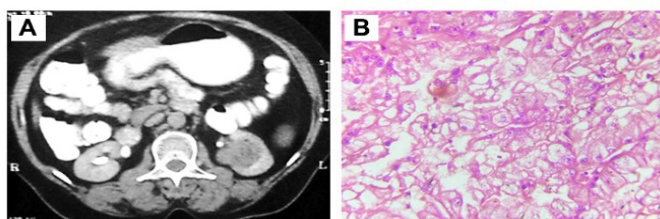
Panel A: CT image of RCC of the left renal pelvis
